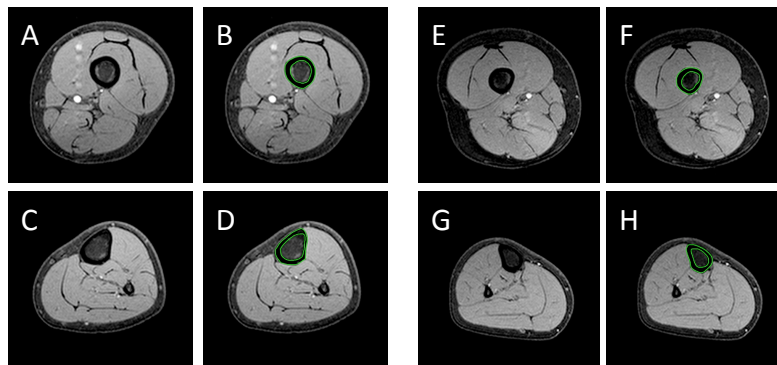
Example MRI images of the proximal femur (A-B,E-F) and tibia (C-D, G-H) for a age and sex matched TD subject (A-D) and CP subject (E-H). Regions of interest (green) are shown in B,D,F, and H identifying the inner and outer cortical bone boundaries for cortical bone CSA calculation.
